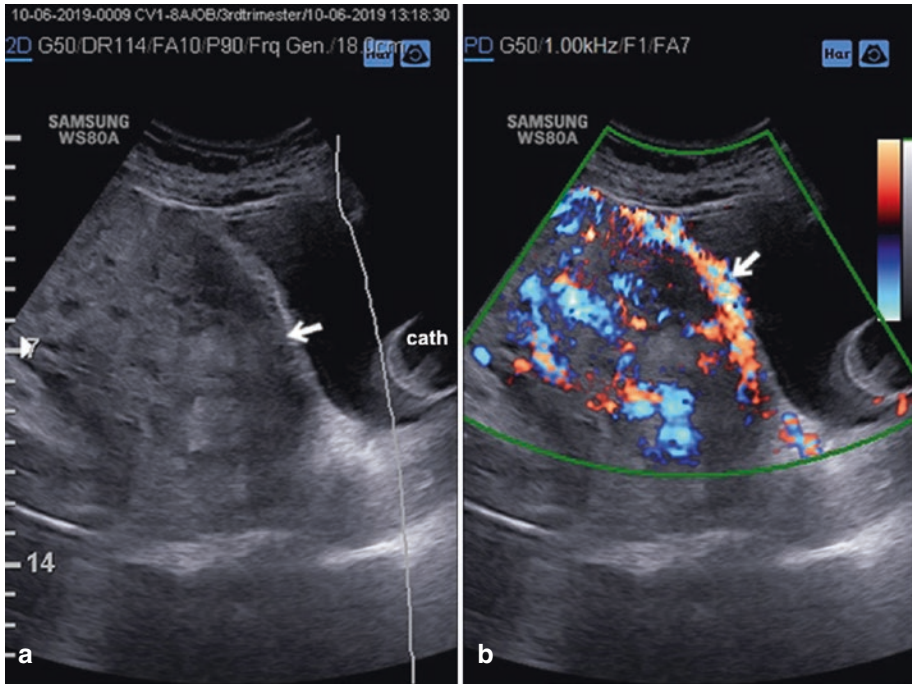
(a) Transabdominal 2D Ultrasound. Loss of “clear zone” (arrow) and (b) Uterovesical hypervascularity in 2D Doppler ultrasound (arrow) in 30 weeks of gestational age
